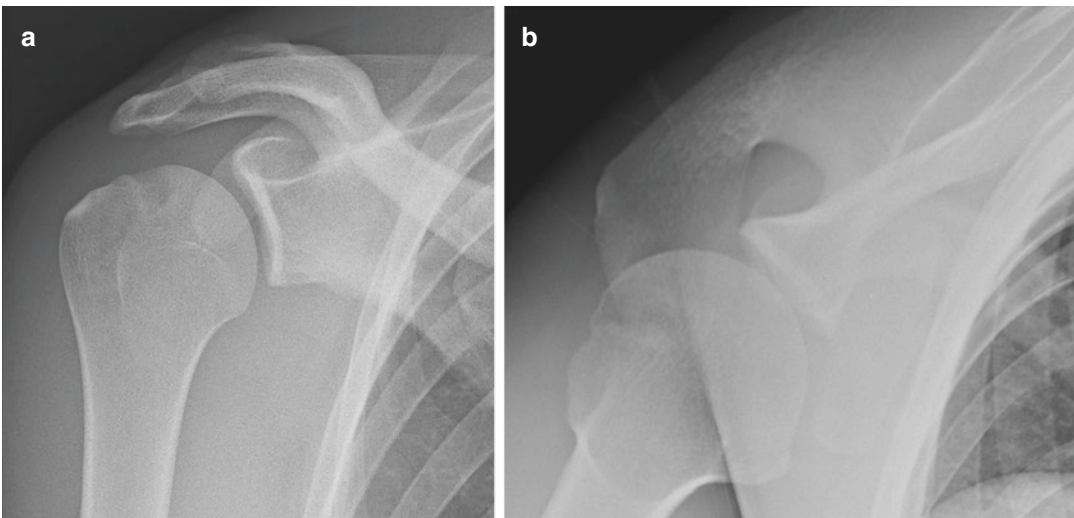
(a) AP view and (b) axillary view X-Rays evidencing bony depression on the posterosuperior area of the humeral head, the Hill-Sachs lesion
